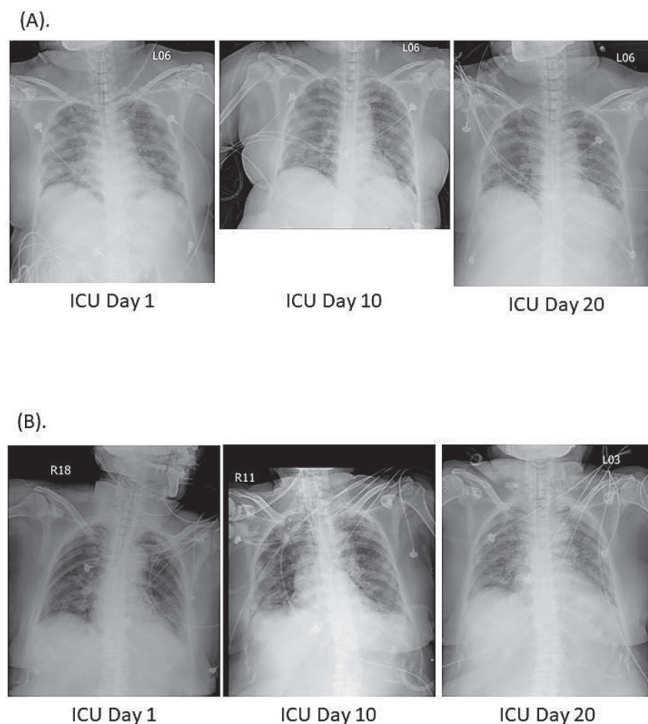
Chest radiography of (A). Patient 1, and (B). Patient 2 during intensive care unit (ICU) stay.
